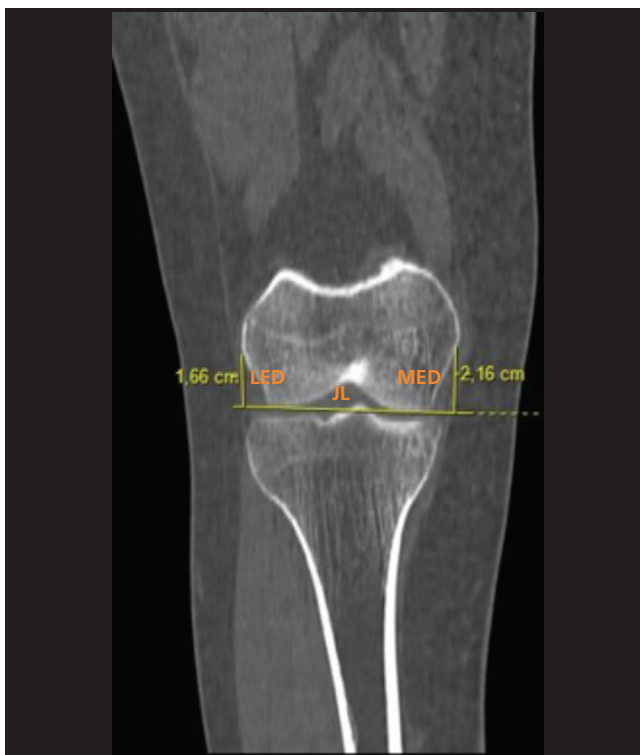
Coronal CT image. Medial epicondylar distance (MED) is the distance between joint line (JL) and the most medial point of the femur where the medial collateral ligament originated and the lateral epicondylar distance (LED) is the distance between JL and the most lateral point of the femur where the lateral collateral ligament originated.
